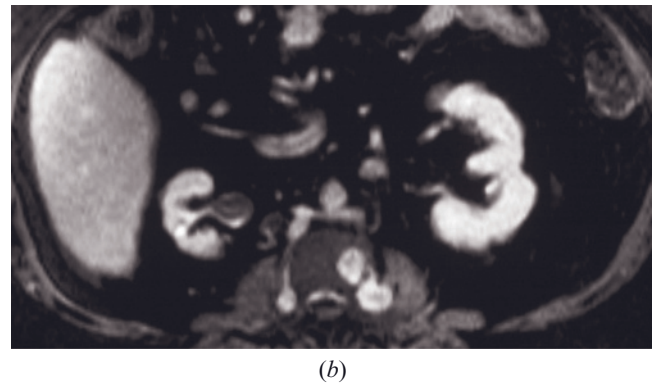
Ischemic nephropathy secondary to Takayasu arteritis. Coronal MIP reconstructed image (a) and interstitial-phase postgadolinium T1-weighted fat-suppressed image (b) in a patient with Takayasu arteritis. The right kidney is decreased in size and shows irregular contour. The right renal artery is significantly reduced in caliber (arrow, a).
